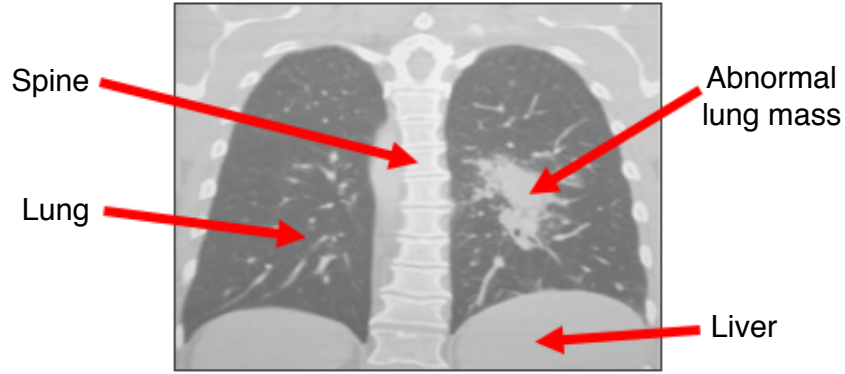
A coronal cross-sectional CT image of the thorax
